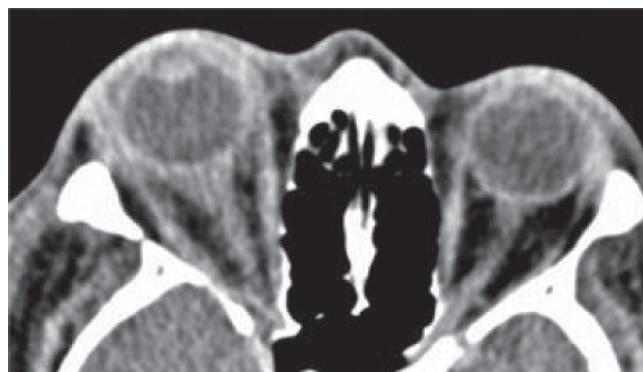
Enhanced axial CT Orbit showing the slightly proptosed right globe. A small soft tissue lesion is seen immediately posterior to the right globe with some ill-defined densities within the retro orbital space suggesting infective or inflammatory process.
